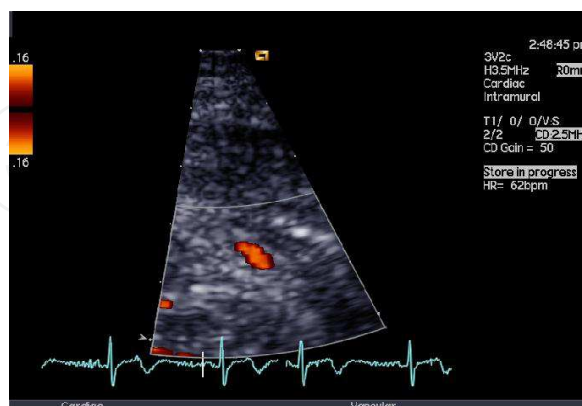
Colour Doppler of the LAD allowing measurement of jet width
